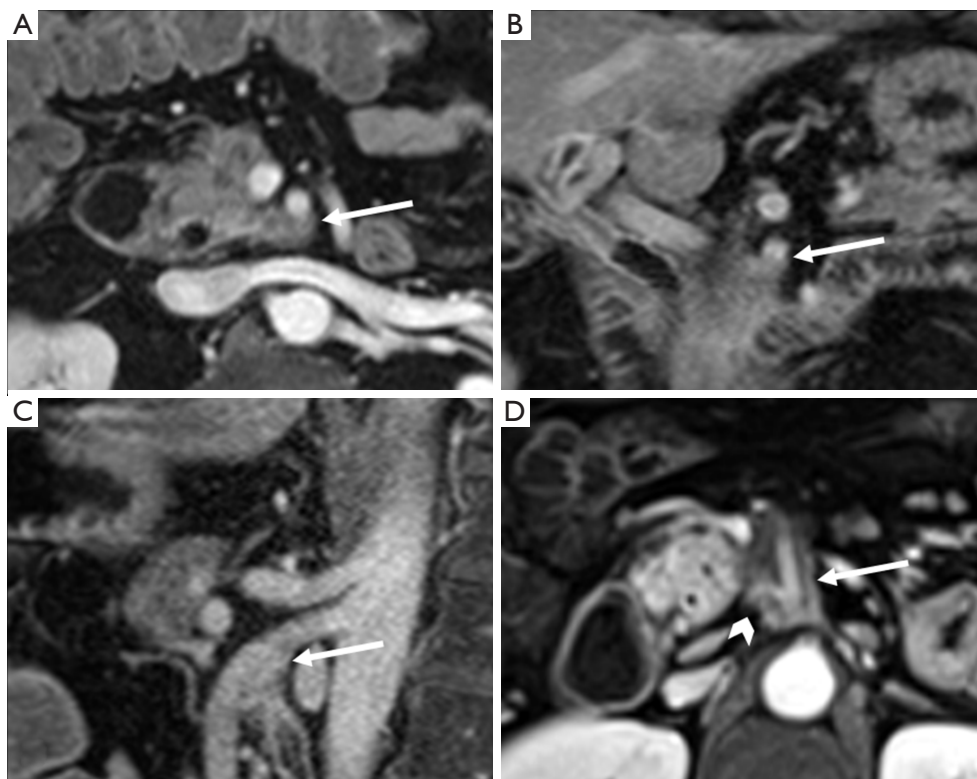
Vascular assessment. Postcontrast MR images in (A) axial, (B) coronal, (C) and sagittal planes in the same patient demonstrate tumor abutment (<180 degrees) with the SMA (arrows). In a separate patient, postcontrast (D) axial MR image shows tumor encasement (>180 degrees) of the SMA (arrow) and replaced right hepatic artery (chevron). MR, magnetic resonance; SMA, superior mesenteric artery.
